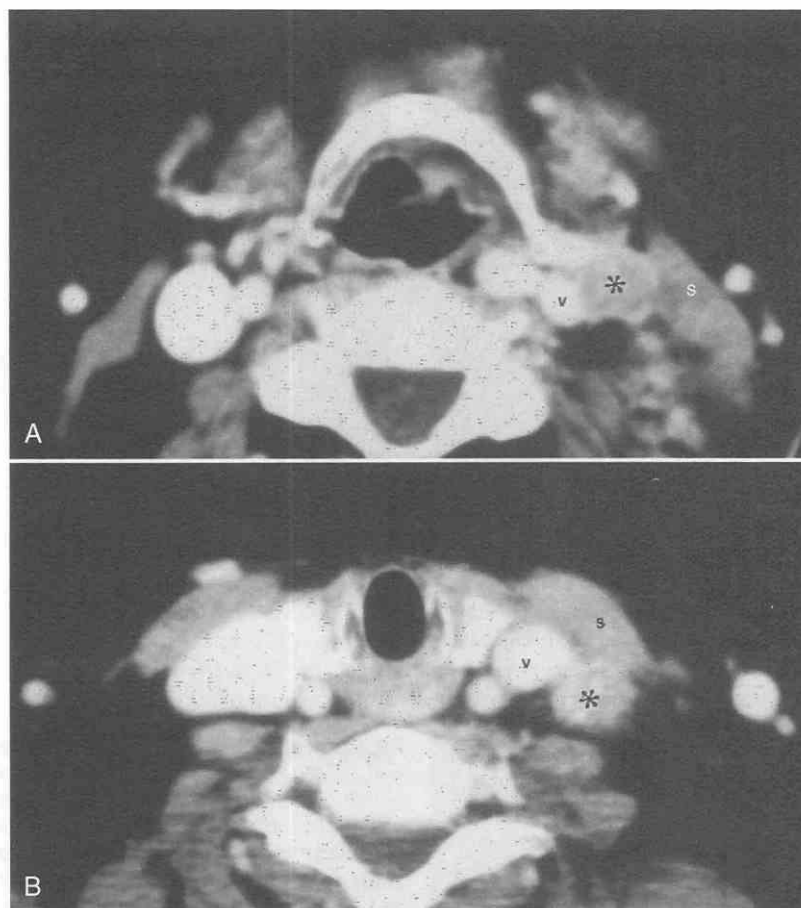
Internal jugular chain lymph nodes. *A*, Axial contrast-enhanced CT scan at the level of the hyoid bone demonstrates a 2-cm-diameter lymph node (*asterisk*) medial to the left sternocleidomastoid muscle (*s*) and lateral to the left internal jugular vein. This lymph node is present at the junction of axial levels II and III. *B*, Axial contrast-enhanced CT scan at the level of the cricoid cartilage demonstrates a 2-cm-diameter lymph node (*asterisk*) immediately posterior to the left internal jugular vein (*v*). This lymph node is present at the junction of axial levels III and IV.
